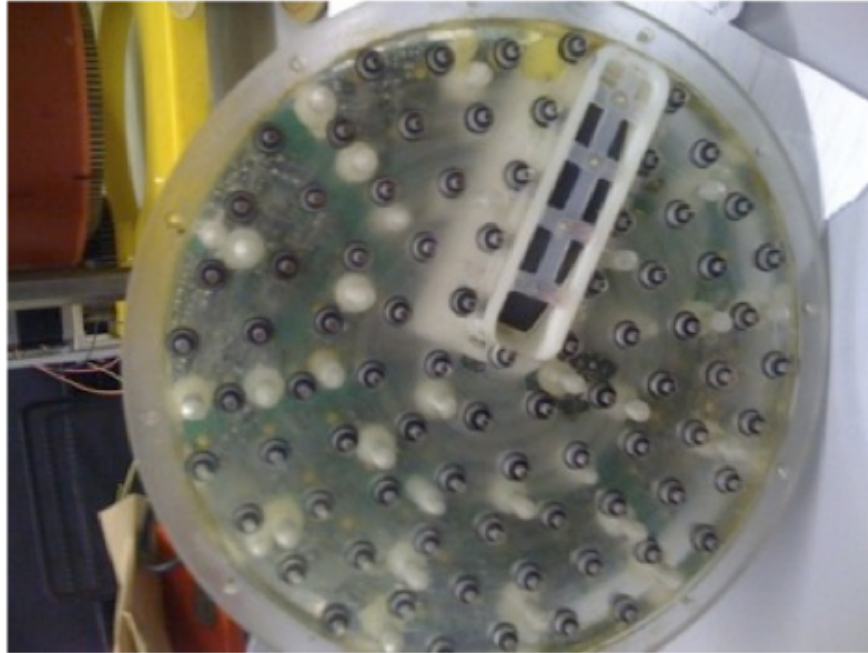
Bridge electrodes on the EIM plate above the ultrasound transducer.
